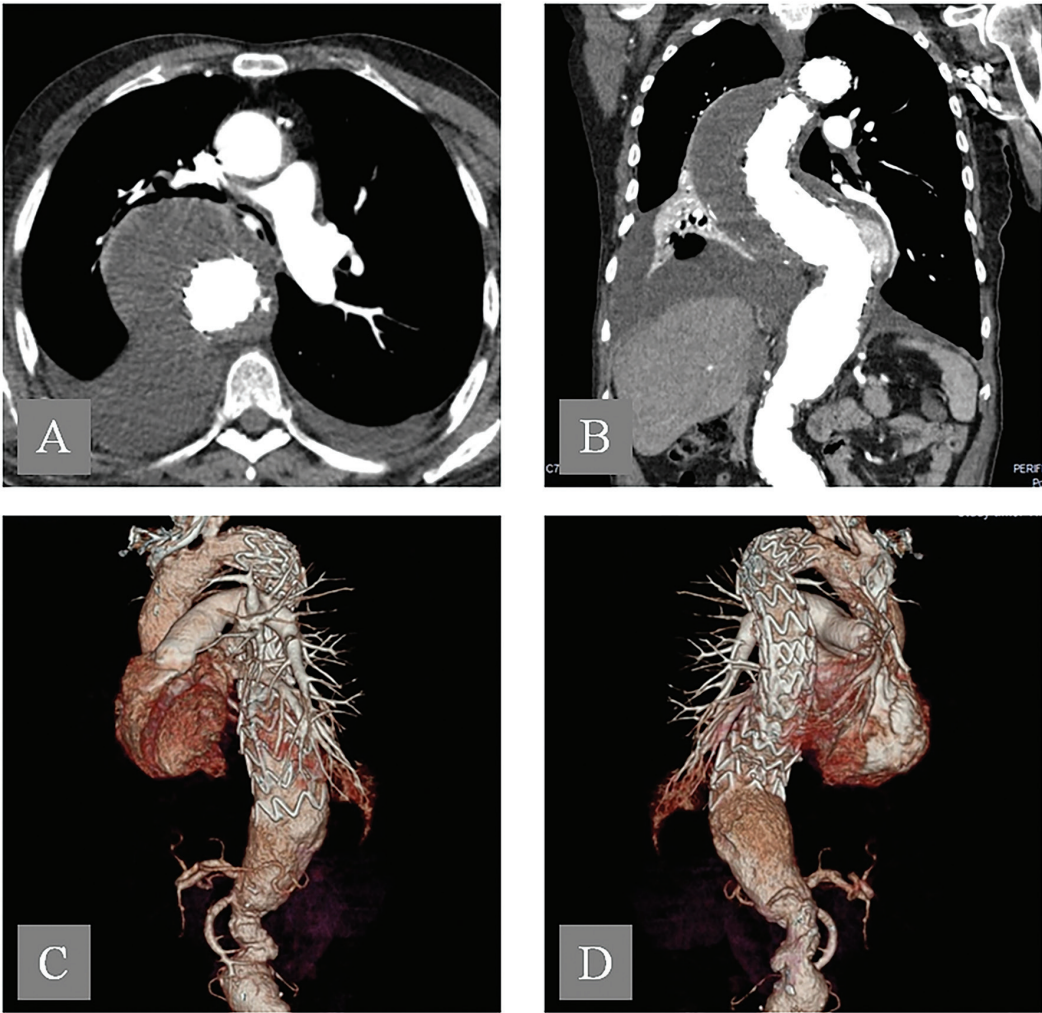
Control CT angiography after 4 months from TEVAR
